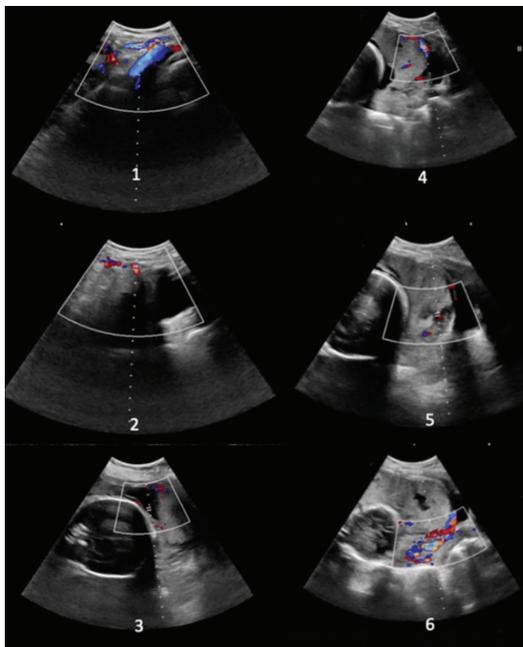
The Doppler sonography in pregnant women with placenta accreta spectrum. (1) The right uterine artery Doppler sonography, (2) The left uterine artery Doppler sonography, (3) The largest lacunae Doppler sonography, (4) The posterior of the bladder Doppler sonography, (5) The posterior lacunae Doppler sonography, (6) Cervix Doppler sonography
